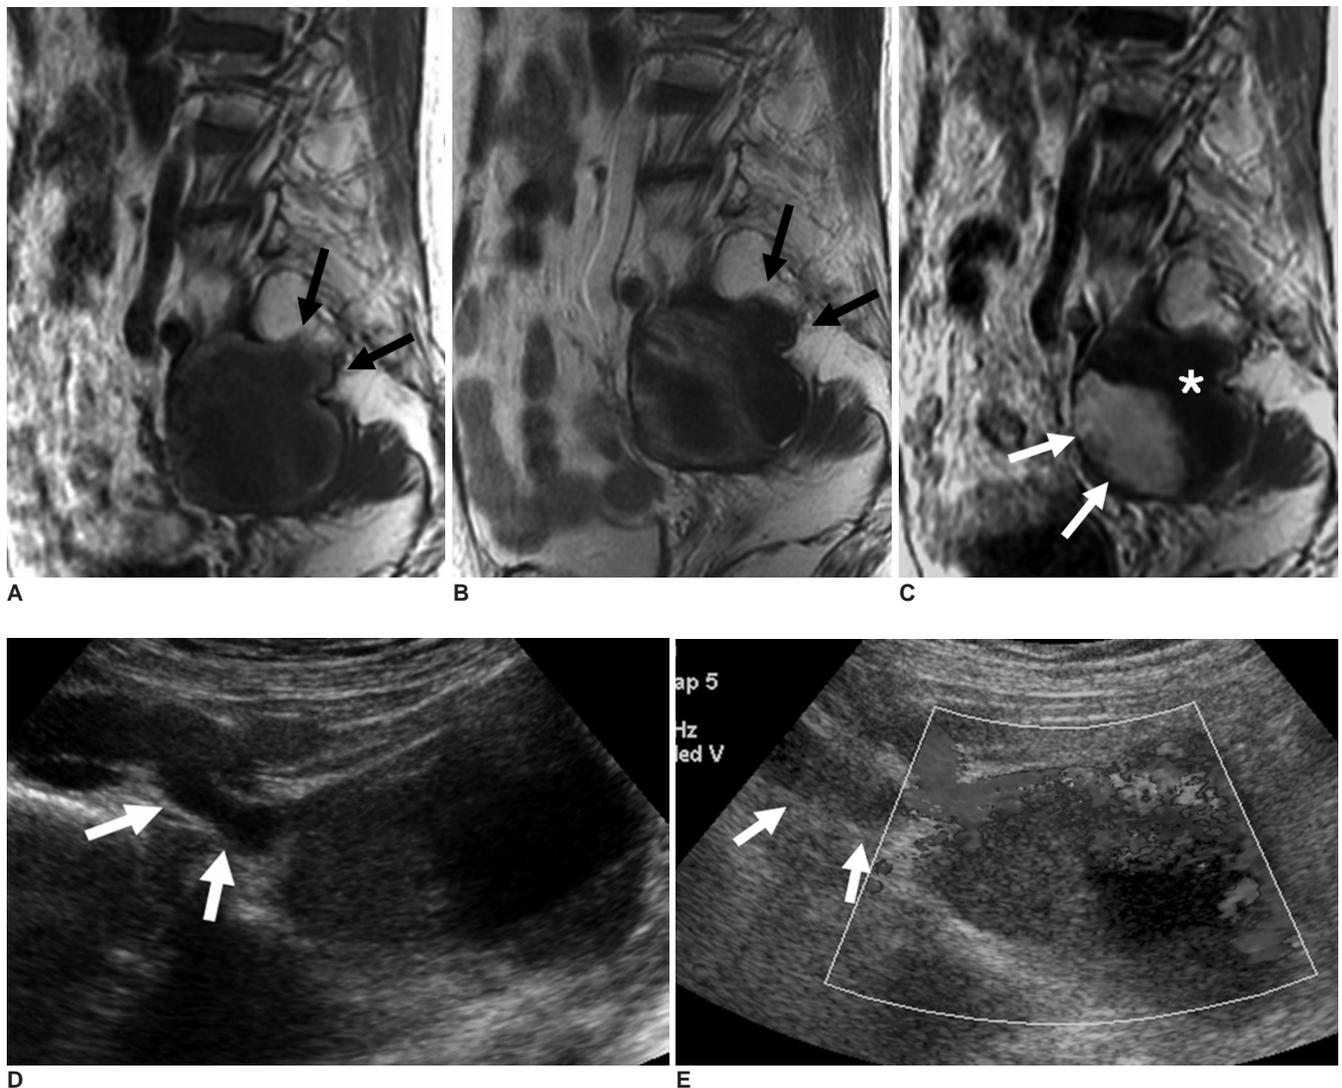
Images of a 57-year-old woman with pelvic pain and weakness of her right lower leg for 8 months. A, B. The sagittal T1-weighted (A) and T2-weighted (B) MR images of the sacrum show a presacral mass with peripheral high signal intensity and central low signal intensity. The sacral foramen is eroded by the presacral mass (arrows). C. The contrast-enhanced sagittal T1-weighted MR image shows strong enhancement in the anterior half of the mass (arrows) and no enhancement in the posterior half of the mass (asterisk). D, E. Pelvic ultrasound (US) shows a cystic mass adjacent to the right internal iliac artery (arrows) in the right pelvic cavity (D). The mass has a lobulated thick eccentric wall laterally, with an anechoic cystic portion that showed turbulent flow on color Doppler US. (E) The mass is connected to the internal iliac artery (arrows).
